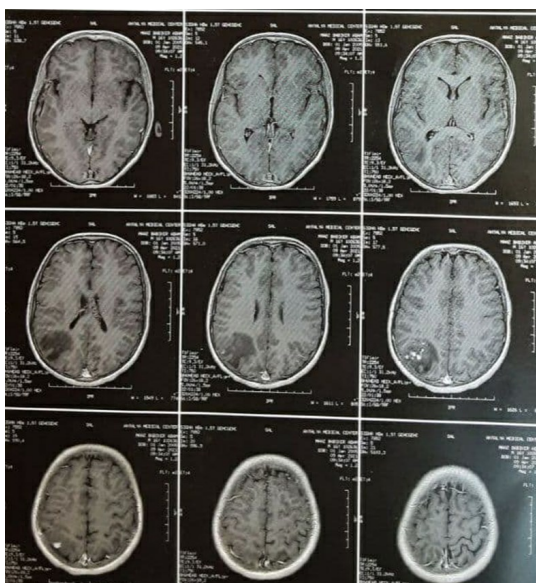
MRI brain T1 with contrast axial cut of the same lesions.
